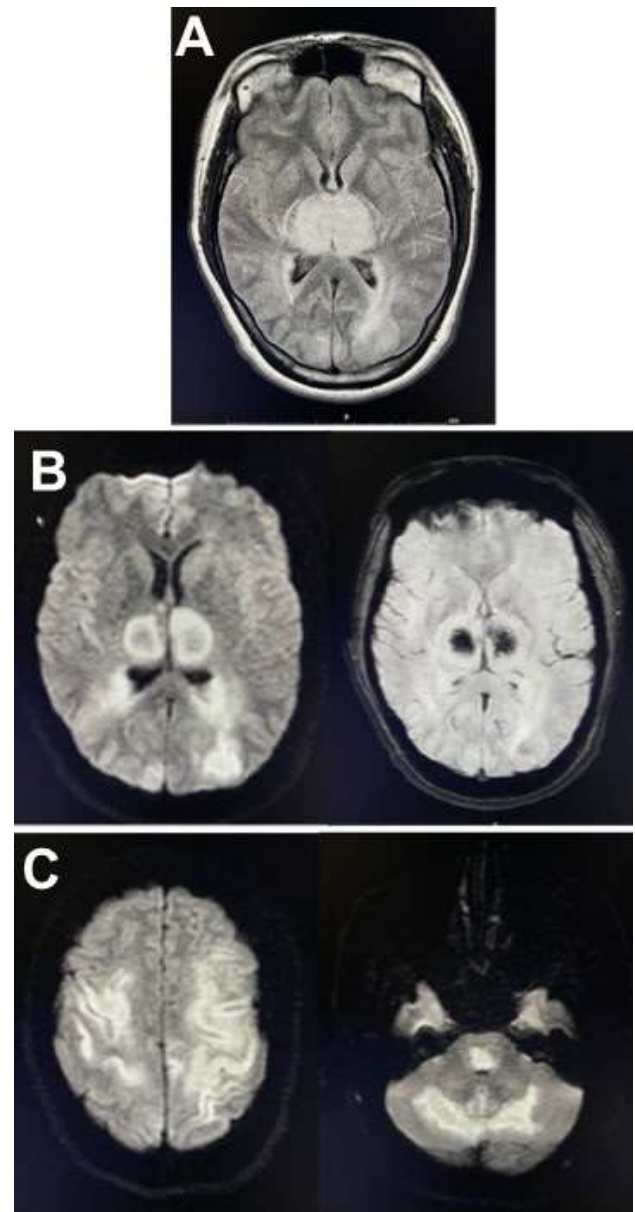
A: T2-weighted image demonstrating bilateral thalamic and L occipital white matter hypoattenuation. B: DWI and GRE images showing bilateral thalamic infarctions with hemorrhage. C: Representative DWI images of cerebrum and cerebellum and pons showing widespread diffusion restriction.
